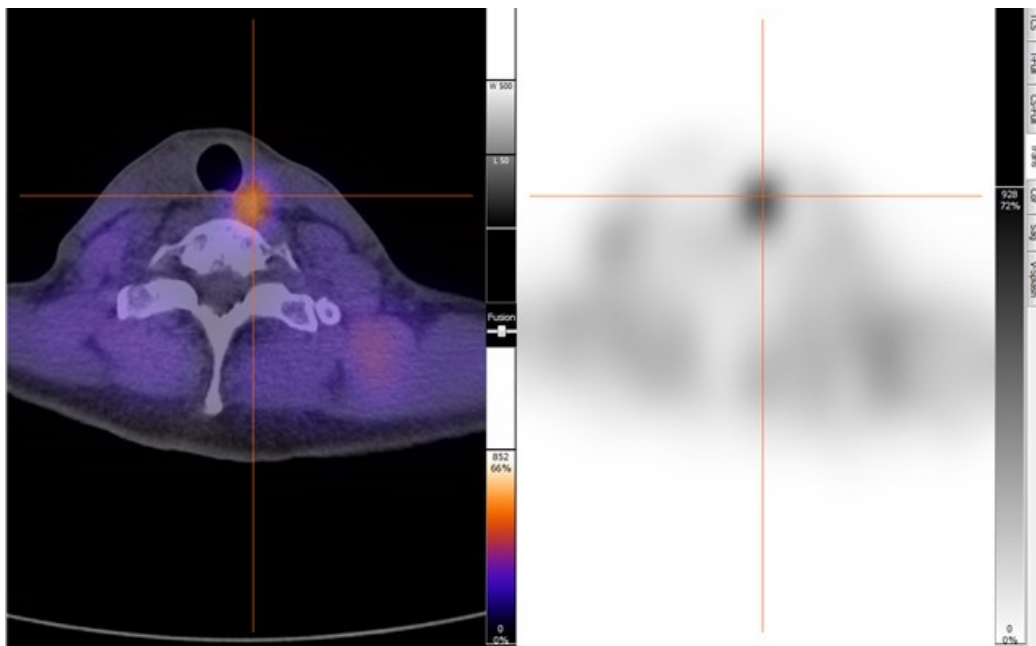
Case 5: SPECT/CT with low-resolution CT suggesting a left paratracheal inferior parathyroid adenoma. On the left, the fused image of SPECT/CT; on the right, the image derived from SPECT.
